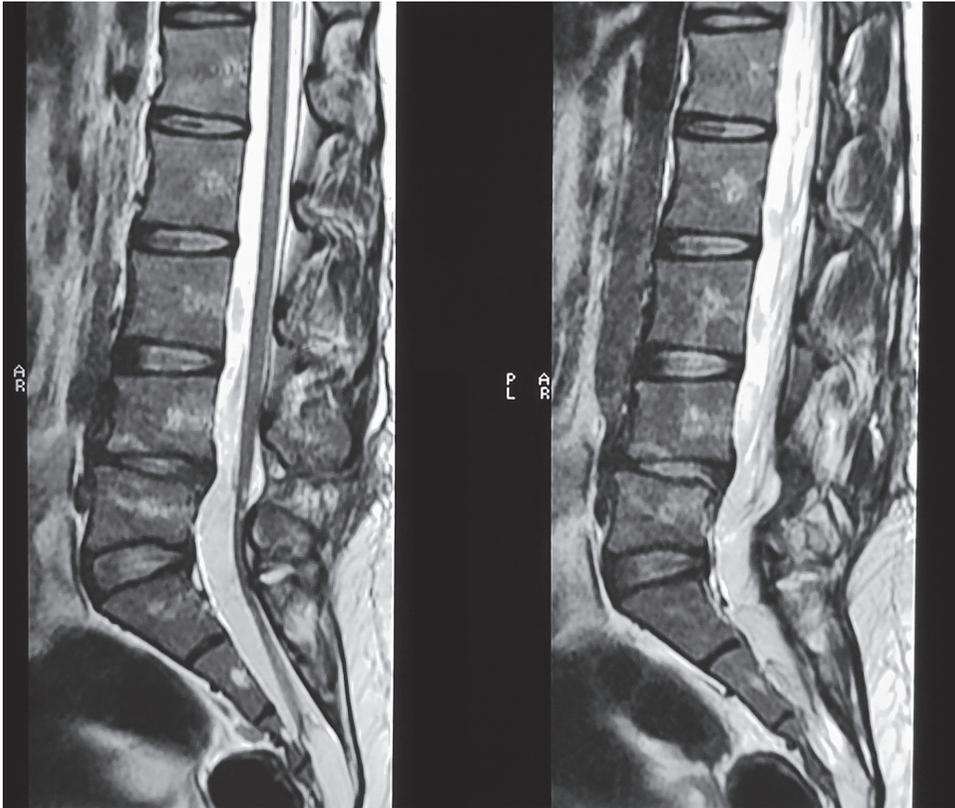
Postoperative sagittal magnetic resonance imaging revealed tethered cord syndrome and a small area of hypersignality in conus medullaris on T2 weighted lumbar spine images.
